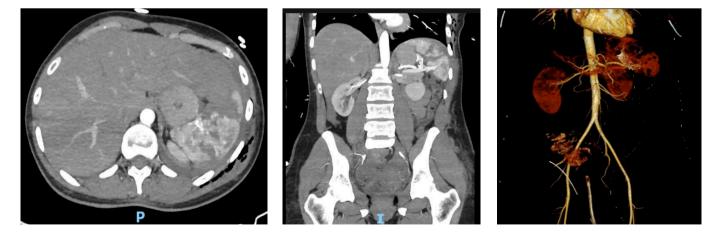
Reassessment computed tomography scan at 48 hours, showing splenic tear (grade IV American Association for Surgery Trauma) and increased intra-abdominal free fluid (hemoperitoneum).
